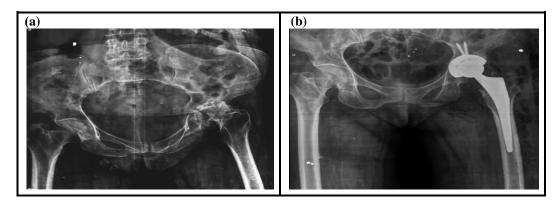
A female case with2ry O.A (AVN) of left hip showing (a) X-ray preoperatively, (b) X-ray post operatively follow up after 6 month
